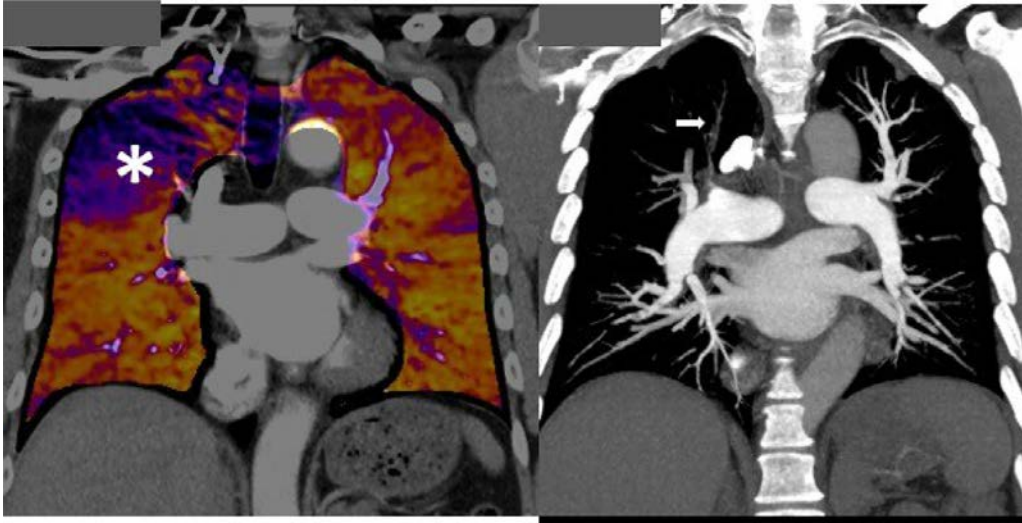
Coronal views of a dual Energy CTPA in a 55 year old with CTEPH. There is a large perfusion defect (*) in the anterior segment of the right upper lobe (Left) with corresponding occlusion (arrow) of the anterior right upper lobe pulmonary artery (Right). CTEPH, Chronic thromboembolic pulmonary hypertension; CTPA, Computed tomography pulmonary angiography.
